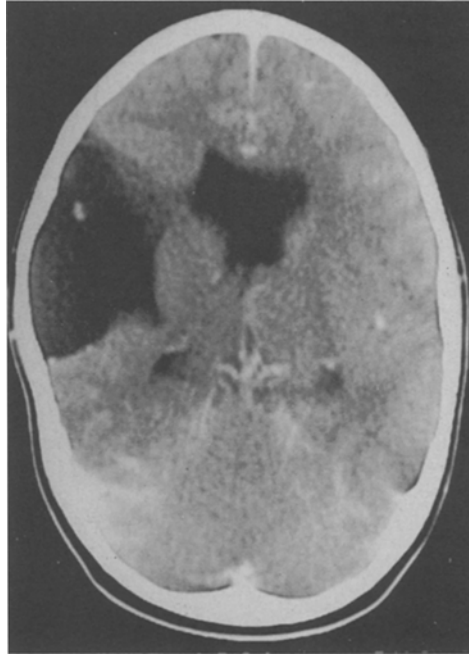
Abnormal computed tomographic scan shows a large porencephalic cyst involving the right temporal region that communicates with the right lateral ventricle. Both lateral ventricles are enlarged. No septum pellucidum is identified.
